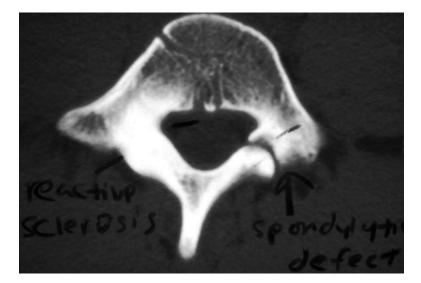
CT scan is the imaging test of choice to define structural anatomy and follow serially to assess bony union
